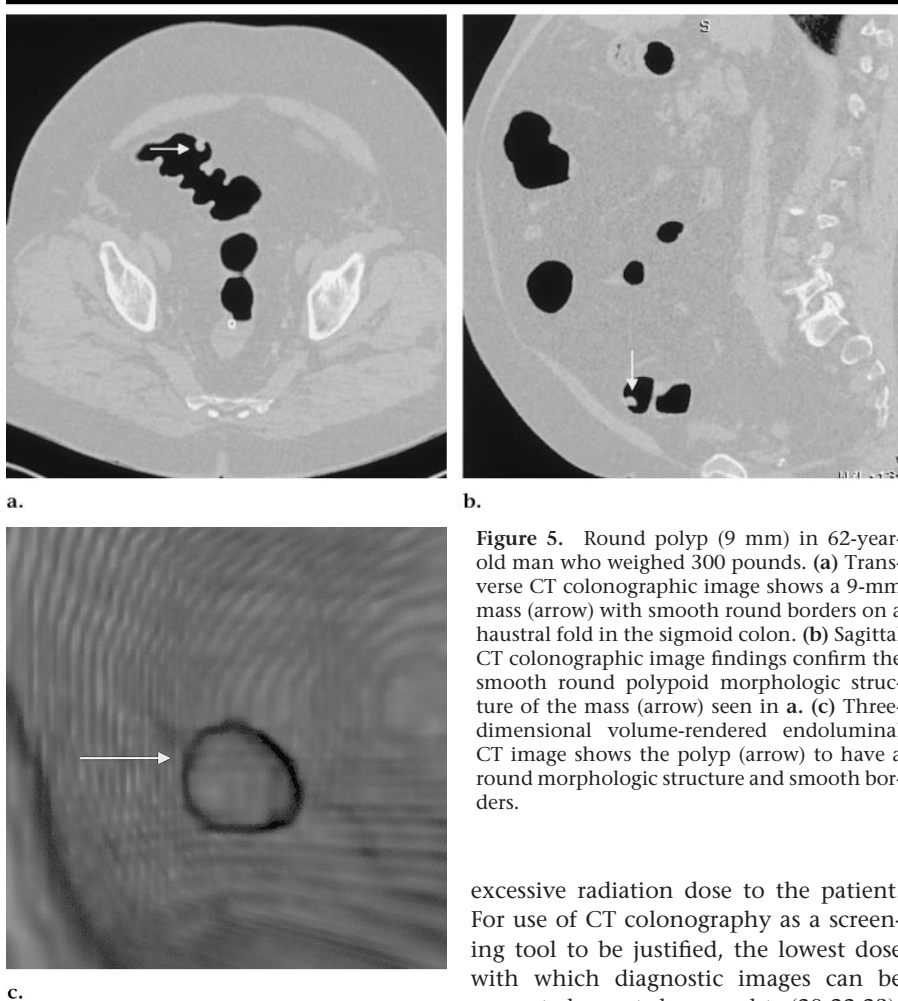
Round polyp (9 mm) in 62-year-old man who weighed 300 pounds. (a) Transverse CT colonographic image shows a 9-mm mass (arrow) with smooth round borders on a haustral fold in the sigmoid colon. (b) Sagittal CT colonographic image findings confirm the smooth round polypoid morphologic structure of the mass (arrow) seen in a. (c) Three-dimensional volume-rendered endoluminal CT image shows the polyp (arrow) to have a round morphologic structure and smooth borders.
